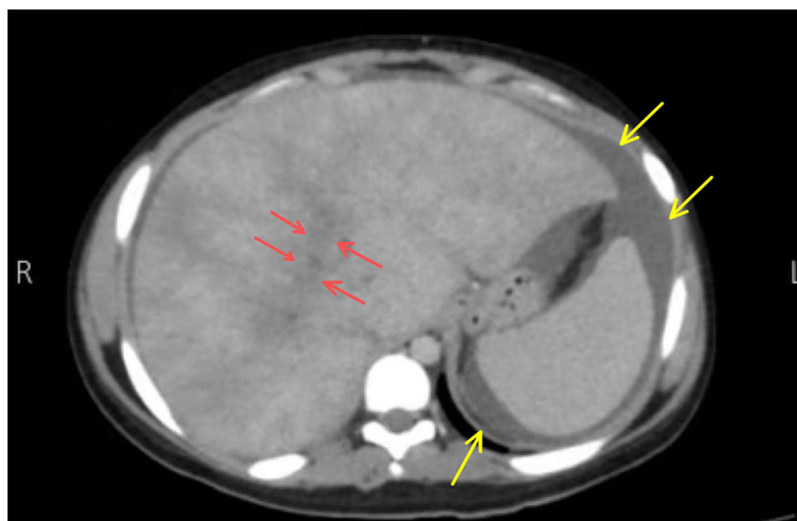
CT scan with contrast reveals an Occluded intrahepatic segment of the IVC and hepatic veins, which are relatively small in caliber (Red arrow), Large ascites (yellow arrow).
